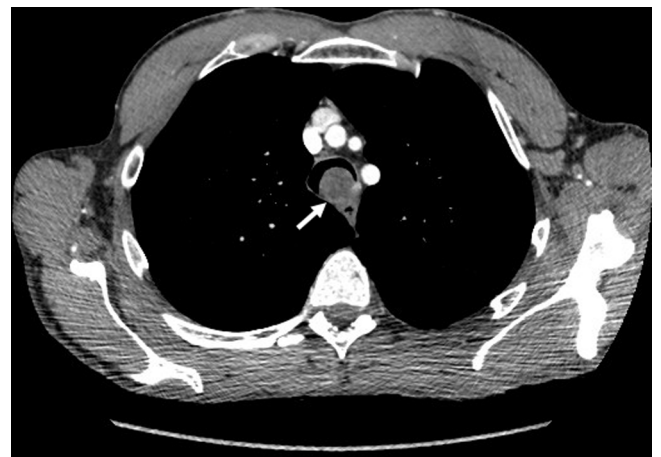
Chest computed tomography scan with contrast showing a hypodense round lesion within the trachea with areas of fatty attenuation and peripheral enhancement (arrow).
